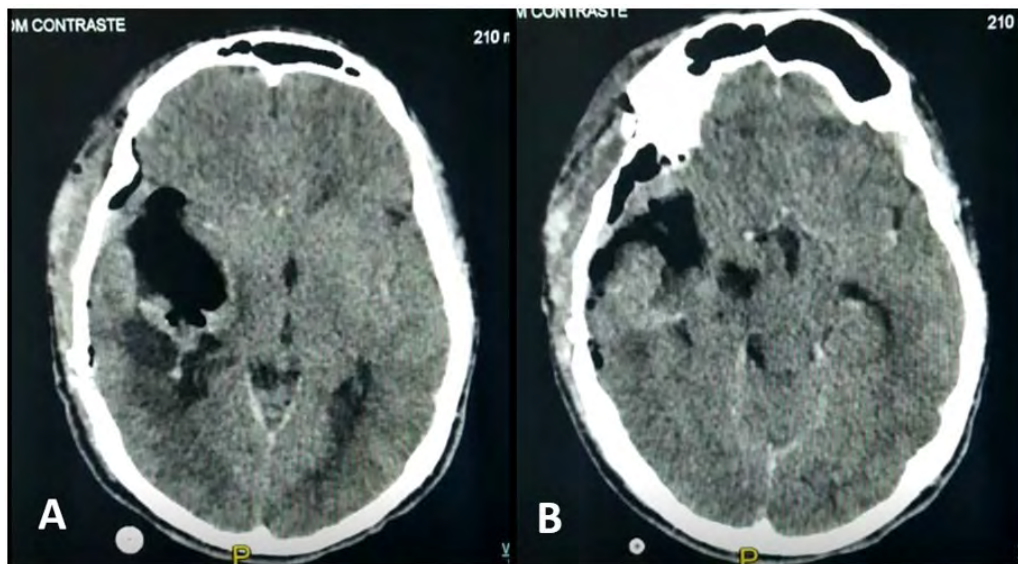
A, B. Post-operative CT (Day 1).
